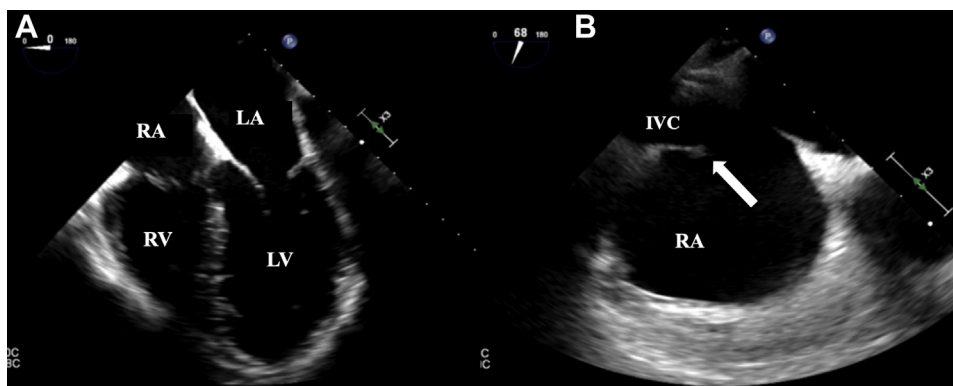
Transesophageal echocardiogram post-procedure. A: Four-chamber view, no evidence of pericardial effusion. B: Mid-esophageal right ventricular inflow 68 degrees showing a prominent Eustachian valve (arrow). IVC = inferior vena cava; LA = left atrium; LV = left ventricle; RA = right atrium; RV = right ventricle.
